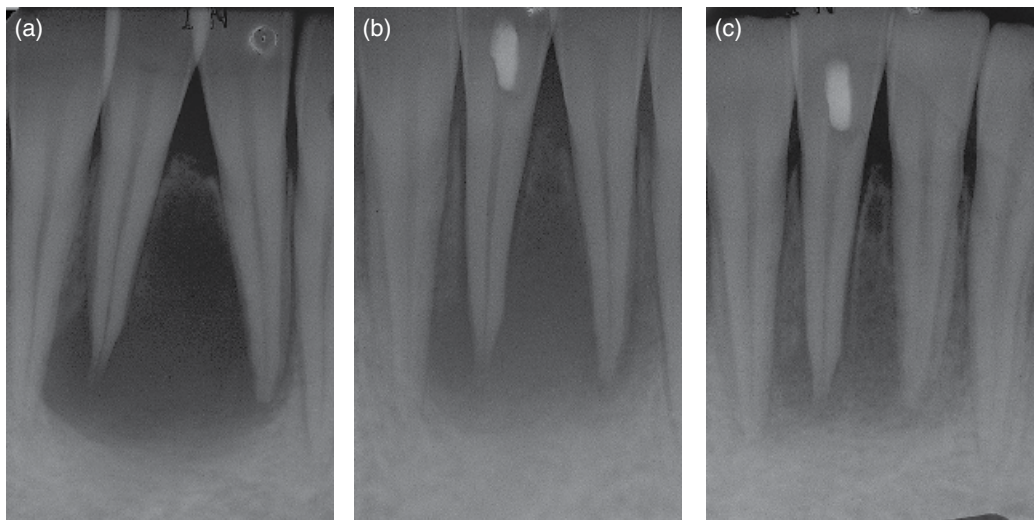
13-year-old patient asymptomatic apart from noticing some firm enlargement facial to his lower anterior teeth. Radiographic evaluation revealed large periapical radiolucency with the roots of the central incisors pushed distally (a). The right central incisor did not respond to cold, but the left one did. Diagnosis of necrotic pulp with chronic apical periodontitis (CAP) was made. Six weeks after placing calcium hydroxide in the root canal system there was significant improvement of the periapical lesion (b). After three months of calcium hydroxide treatment there was almost complete resolution of the lesion (c).
